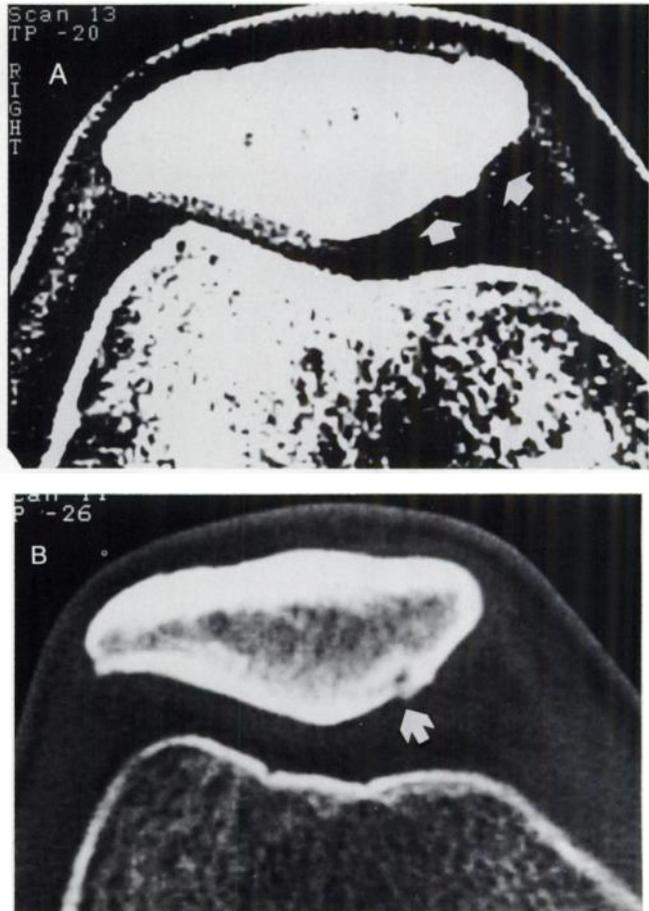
(A) An axial measure-set CT scan through the right patella in Patient 1 (Fig. 1A) with CP shows denudation of retropatellar cartilage with focal bone excrescence (arrows). (B) Axial bone-mode CT scan through the same level reveals focal osteophyte and cyst in the ridged area between medial and odd facets (arrow).
